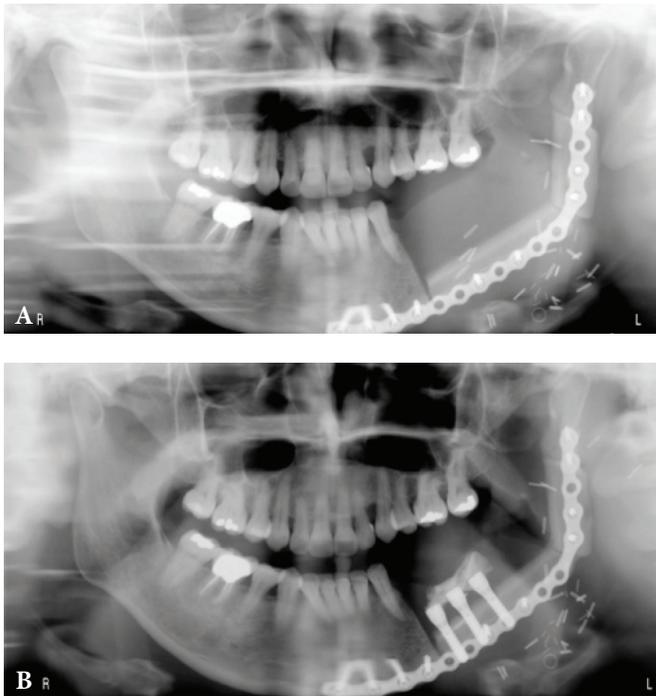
A – Immediate post-operative panoramic radiograph of free fibula flap reconstruction; B – 3 months post-reconstruction panoramic radiograph after dental implant placement and flap debulking.
